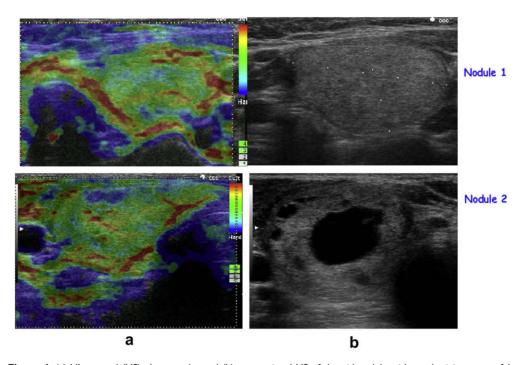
(a) Ultrasound (US) elastography, and (b) conventional US of thyroid nodule with an elasticity score of 1.
